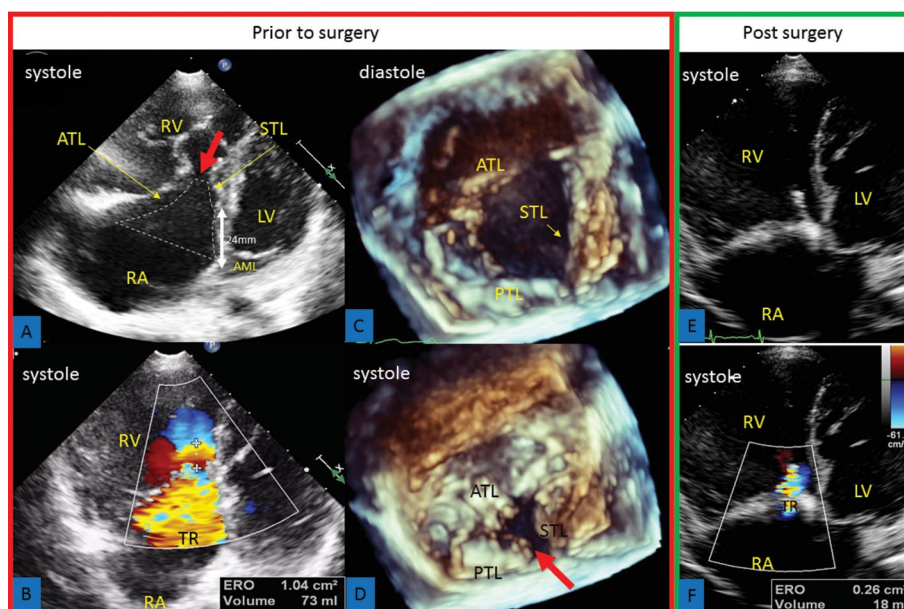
Modified 4-chamber view (panels A and B). Typical for Ebstein's anomaly displacement of the septal tricuspid leaflet (STL), it is located at a distance of 24 mm from the anterior mitral leaflet (AML) – white arrow. The atrialized portion of the right ventricle is shown by the dashed line. The coaptation gap (red arrow) cause severe tricuspid regurgitation (TR) shown on panel B. Three-dimensional echocardiography (panels C and D) presenting diastolic and systolic views of the tricuspid valve confirm a large coaptation defect (red arrow) caused by pathology of the STL and annulus dilatation. Panels E and F show improved coaptation and a significant reduction in regurgitation after surgical plasty of the tricuspid valve. It was confirmed by significant reduction in the effective regurgitant orifice (ERO) and regurgitant volume; ATL – anterior tricuspid leaflet; RV – right ventricle; LV – left ventricle; RA – right atrium; PTL – posterior tricuspid leaflet
